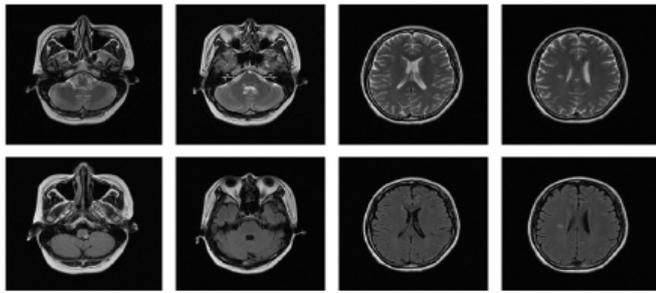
Brain MRI was repeated in November 2021, which didn't show any new active lesions.
